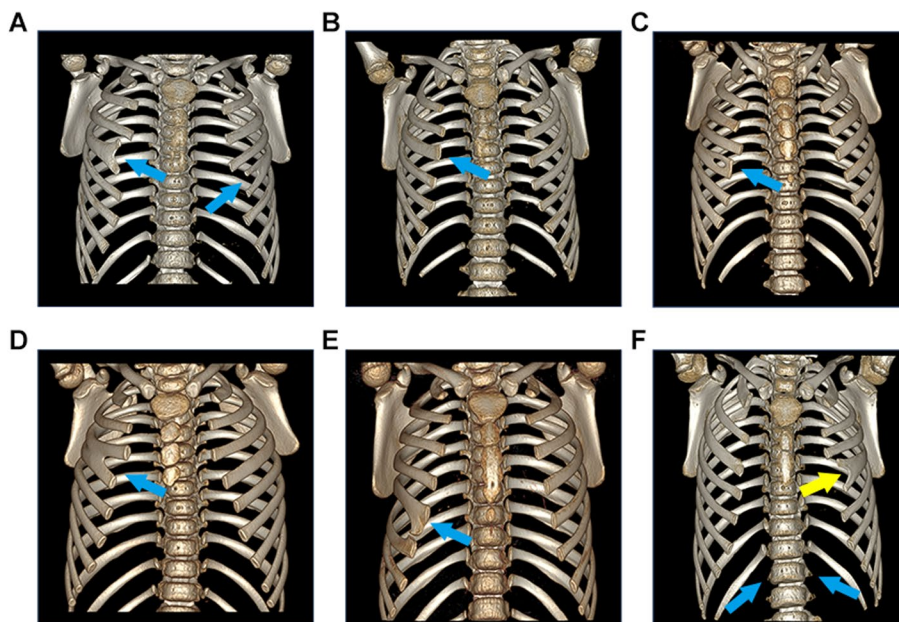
3D volume rendering multidetector computed tomography (MDCT) images showing the rib deformity. A-C top panels from left to right; D-F bottom panels from left to right. A-C Three different cases of bifid rib type congenital abnormality; A Fork type bifid ribs (arrows); B Enlargement in the rib (widened type, arrows); C Hole type (arrows); D Costal Fusion between the anterior parts of the right 3st and 4th ribs; E Costal bridges (blue arrows) in the anterior parts of the right 6th and 7th ribs, (blue arrows); F Aplastic ribs (11 pairs of ribs) and fork type bifid rib in the left 4th rib (blue arrows)
